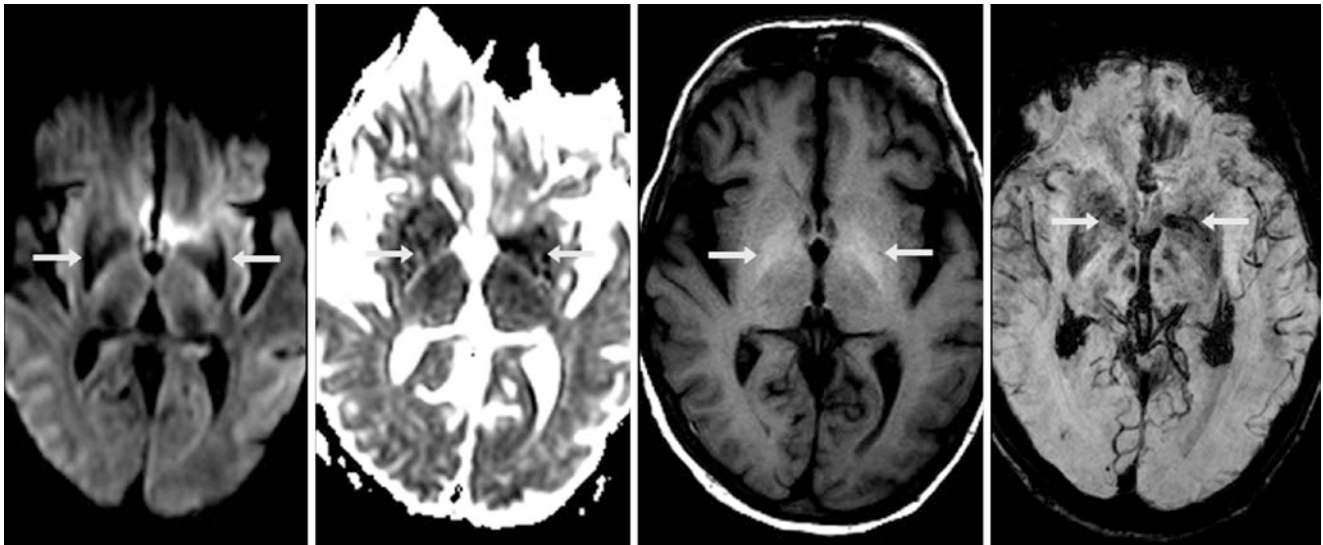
A 56-year-old with chronic hepatic failure had moderately T2-dark signal (*arrows*) that caused a milder degree of T2 blackout within the lentiform nuclei (especially the globi pallidi) on a 1.5 T MRI with DWI (*left*) and ADC map (*left middle*). The blackout in this patient
